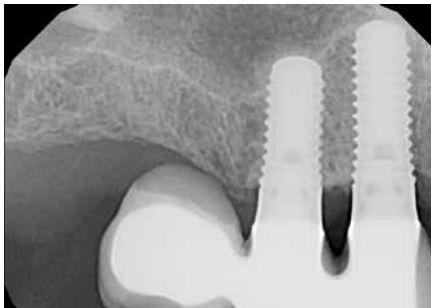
3j Radiographic signs of osseous healing noted at 9.5 months post-surgery.
